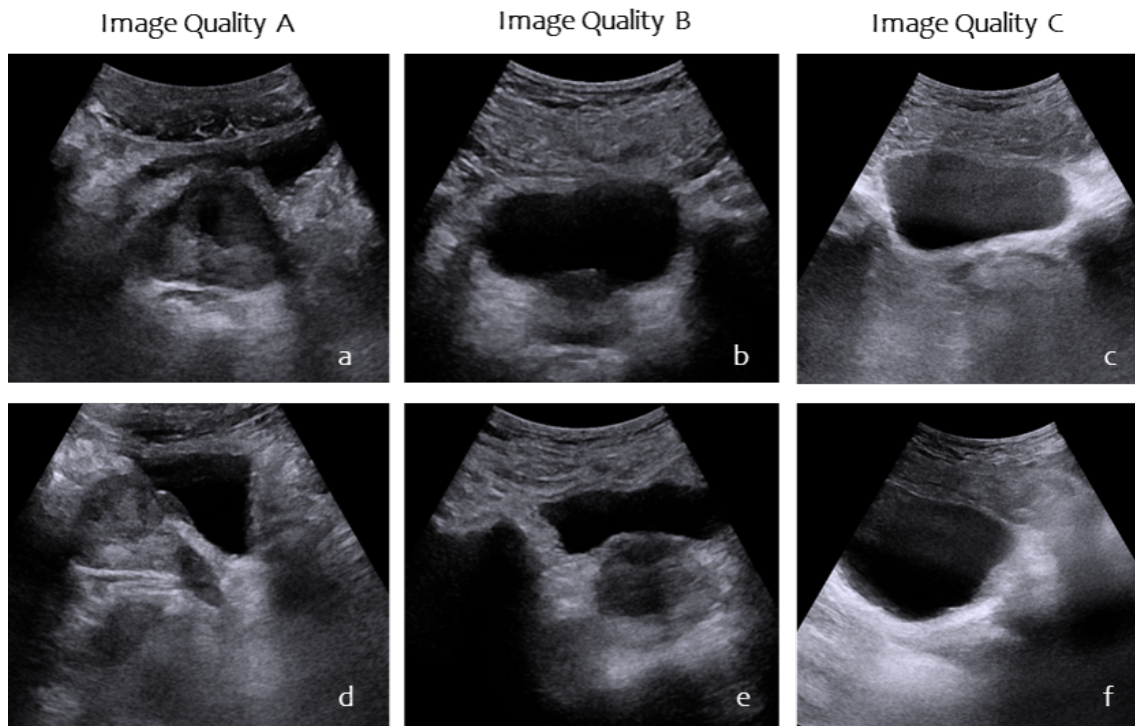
The prostate on transabdominal ultrasound images with diverse image quality. a: Axial quality A image. b: Axial quality B image. c: Axial quality C image. d: Sagittal quality A image. e: Sagittal quality B image. f: Sagittal quality C image.
